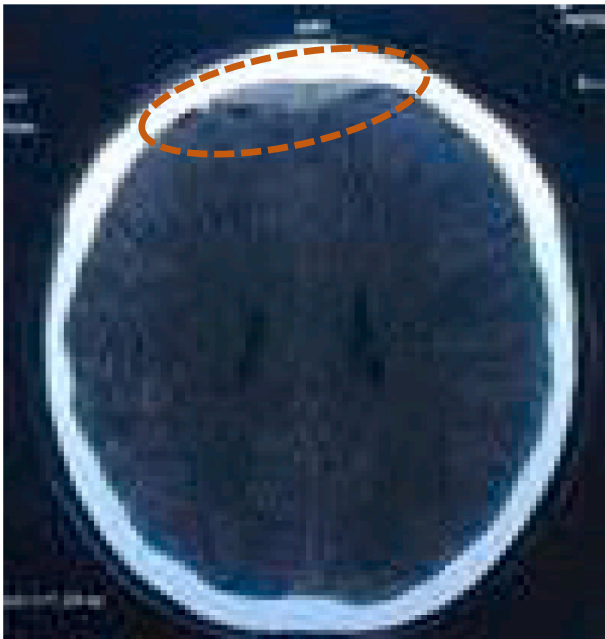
Cerebral CT-scan, without injection, in axial sections, showing a bifrontal extradural hematoma.
